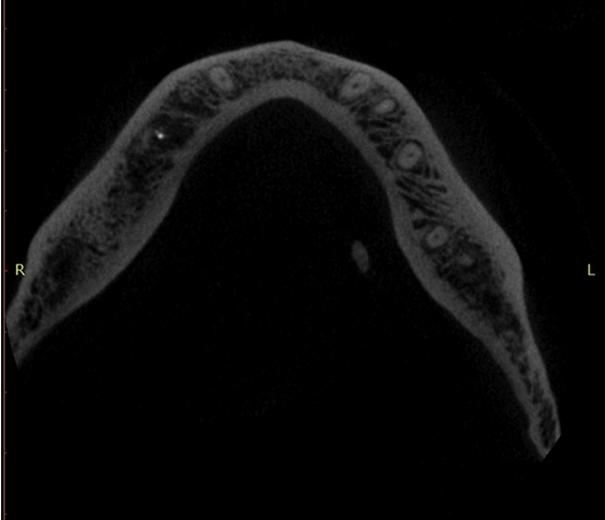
Patient 3. Cone-beam computed tomography image of a patient with a left submandibular sialolithiasis demonstrating 1 calculus in the glandular infundibulum and another in the middle third of Wharton's duct. Transverse sectional view of the ductal calculus showing its location in relationship to the roots of the first mandibular molar.
